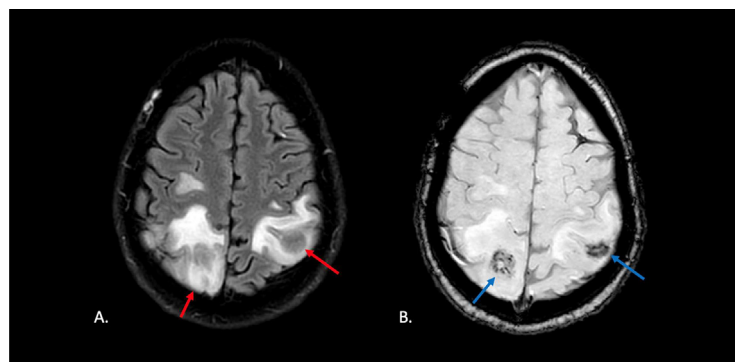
Column A. shows an axial section of a T2 FLAIR sequence Brain MRI, demonstrating intracranial PCNS-PTLD lesions (red arrows). Column B. shows a corresponding axial sections of a gradient echo sequence of a brain MRI; the blue arrows depict the peripheral pattern of punctate intratumoral susceptibility signal.
